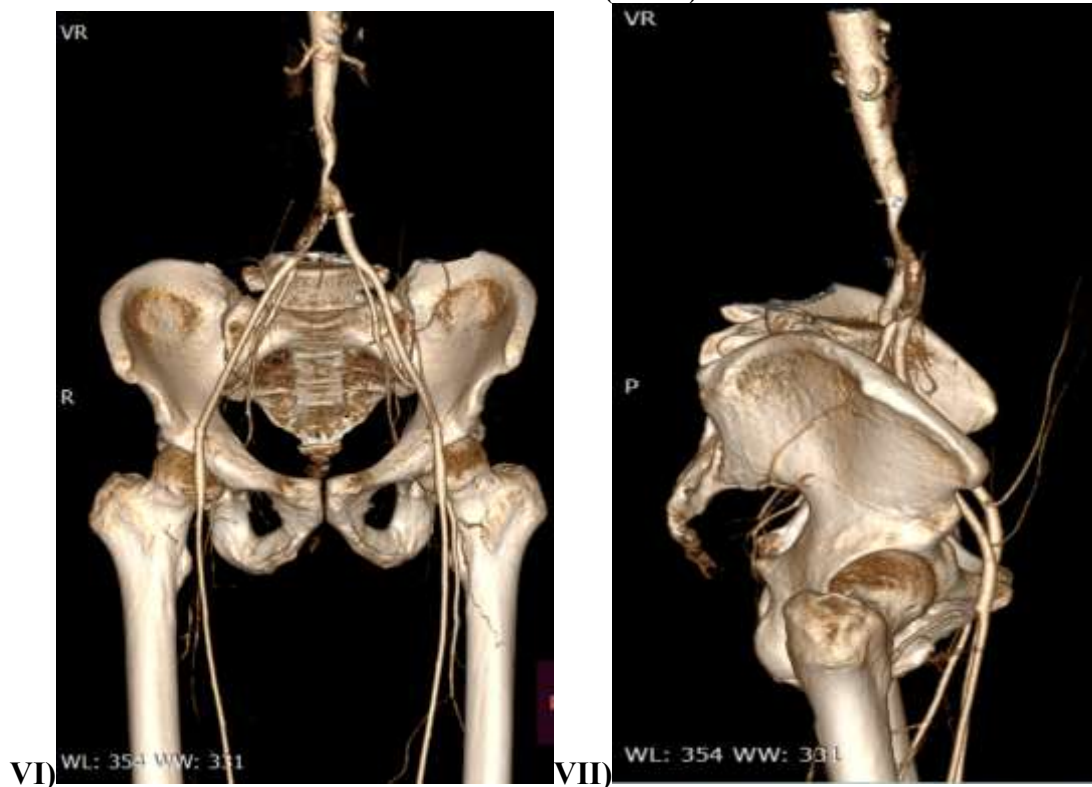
Image- VI, VII)- 3-D CT contrast angiography reconstruction image- frontal and lateral view- showing partial luminal narrowing of infra- renal abdominal aorta with normal contrast filling of its branches
